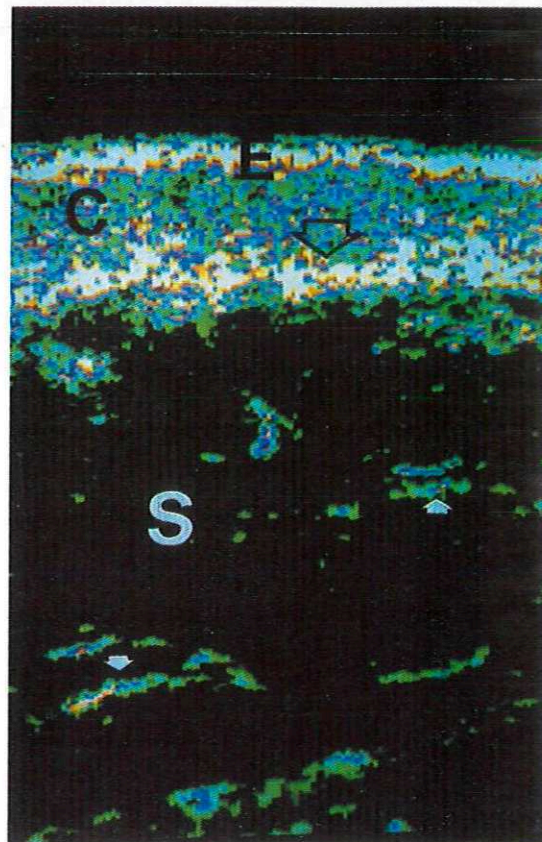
Ultrasound B-scan of the plaque from Fig. 9 two months later (Case Study 4) (E: entry echo; C: corium; S: subcutaneous fatty tissue; open white arrow: enhanced reflexes; small white arrows: hyperechoic bands of connective tissue).
